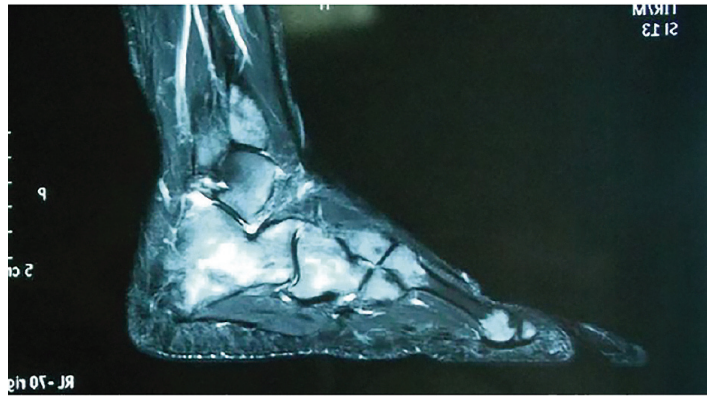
Nuclear magnetic resonance imaging of the foot.
